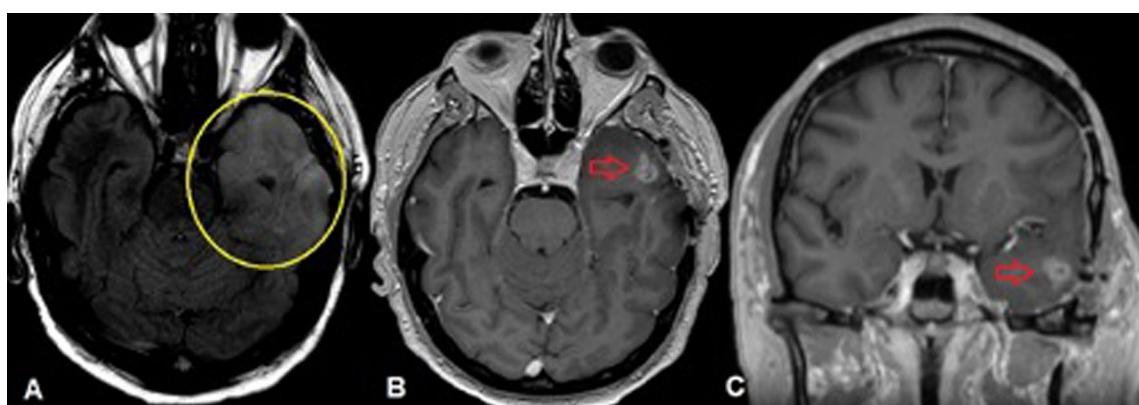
MRI cerebral axial cuts (A and B) and coronal (C) displaying increased FLAIR component (yellow circle) and contrast uprising lesion (red arrows)
